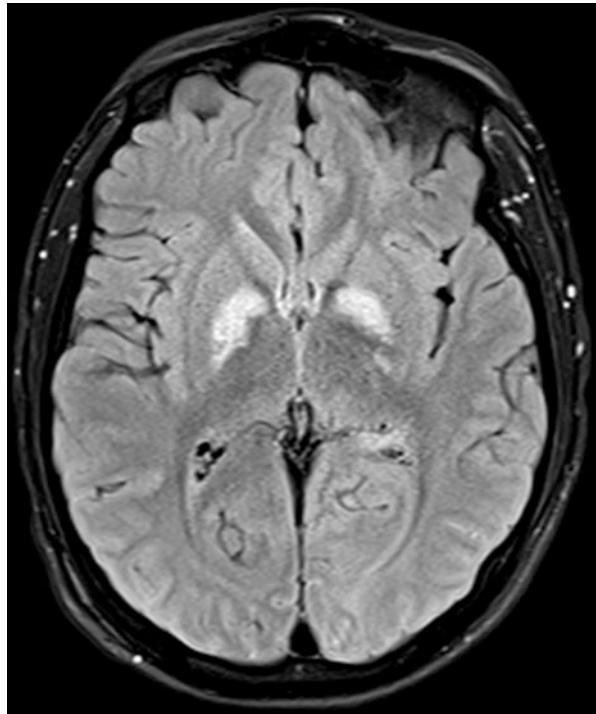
MRI diffusion-weighted imaging (DWI) sequence demonstrates acute infarcts in the basal ganglia (a) and specifically in the globus pallidus bilaterally (b), as well as in the bilateral cerebellar hemispheres (c) and mesial temporal lobes (d)
